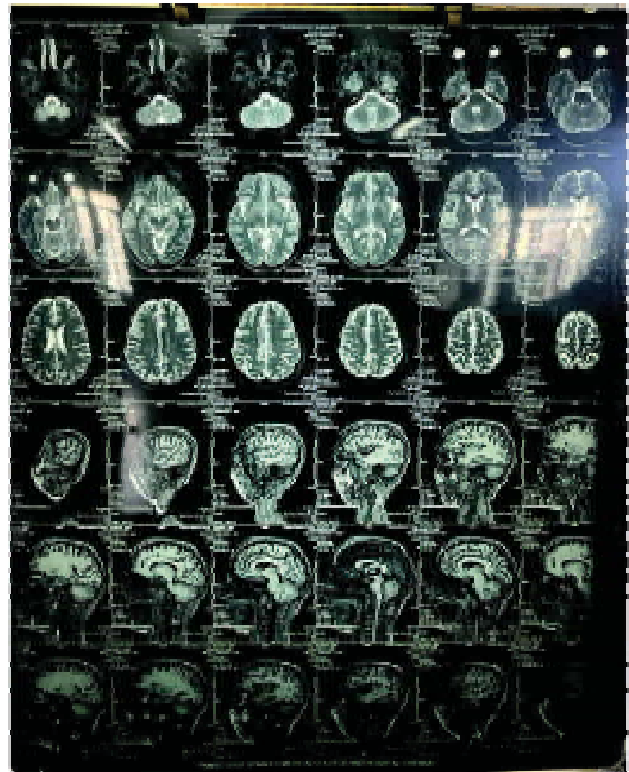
MRI brain: Axial and sagittal view.
